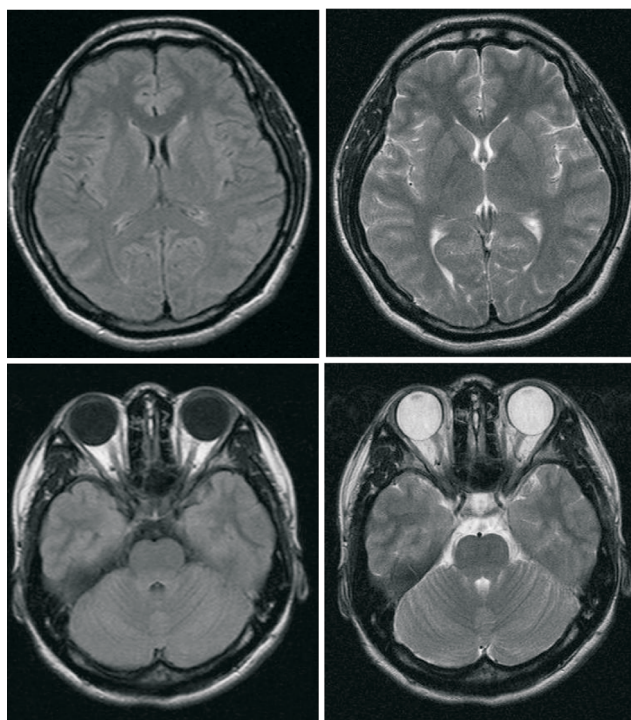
The follow-up head MR revealed complete resolution of brain lesion on the previous head MRI study.
